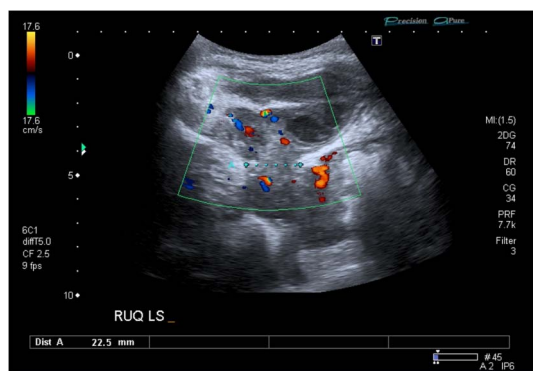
The lesion does demonstrate peripheral Doppler signal and appears continuous with the peritoneum.
